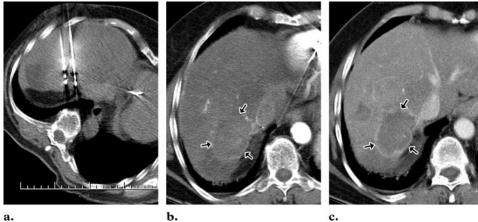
Microwave ablation of a hepatic metastasis in an 82-year-old woman with a cardiac pacemaker and metastatic colon cancer to both lung and liver. She had responded well to chemotherapy and had only one hepatic lesion, measuring approximately 4.3 cm in greatest diameter, in liver segment 7. (a) CT scan shows three single microwave antennae, which were positioned with fluoroscopic guidance in the center of the lesion. Two 10-minute, 45-W ablations were performed. (b, c) Contrast-enhanced CT scans obtained immediately after the procedure in the arterial (b) and portal venous (c) phases show successful microwave ablation of the lesion, with an area of thermocoagulation (arrows) measuring 5.3 cm in greatest diameter. Surrounding peripheral hyperemia represents postablation changes at the site of the lesion. No immediate complications were observed.
